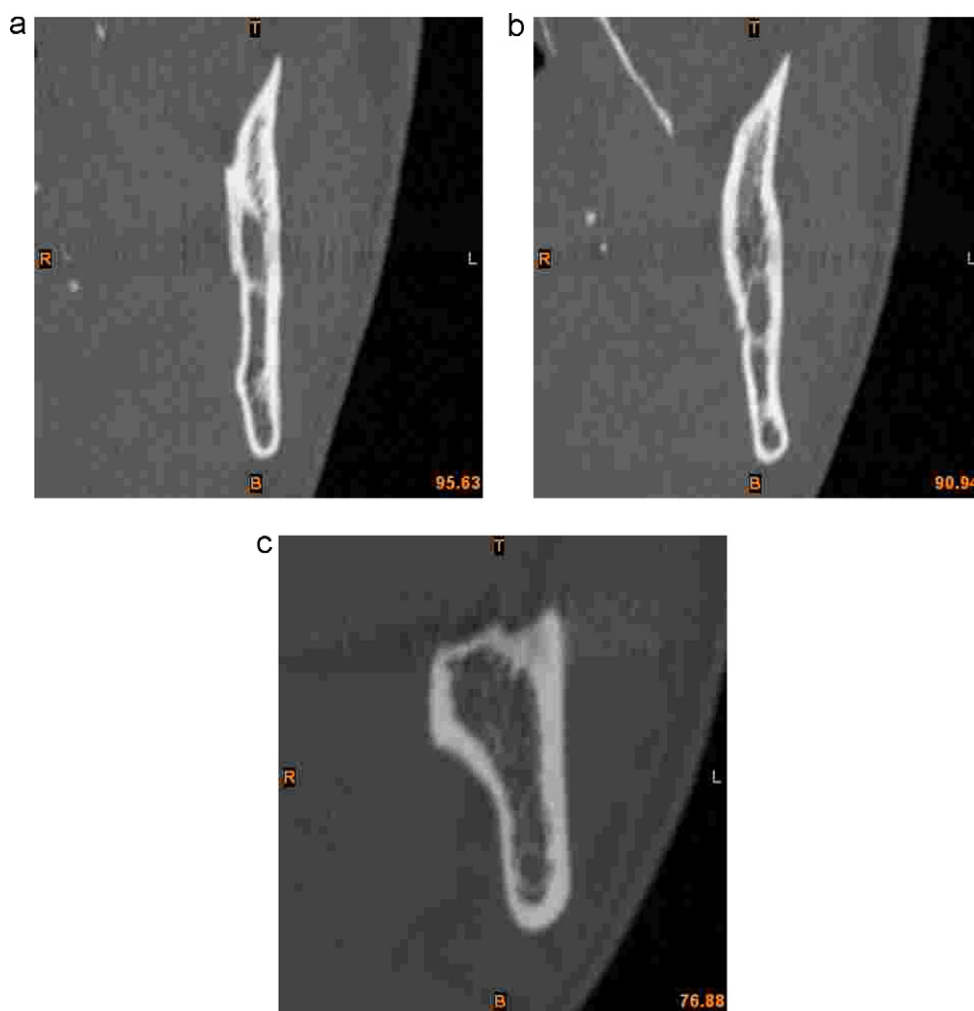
Coronal CT showing proximity at both the buccal and lingual cortices at positions (a) X1, (b) X2 and (c) X3.
